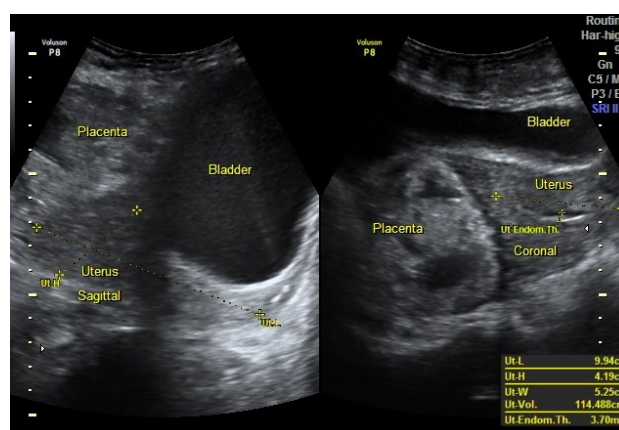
Ultrasound image of the placenta *in situ* on 4th postoperative day.
